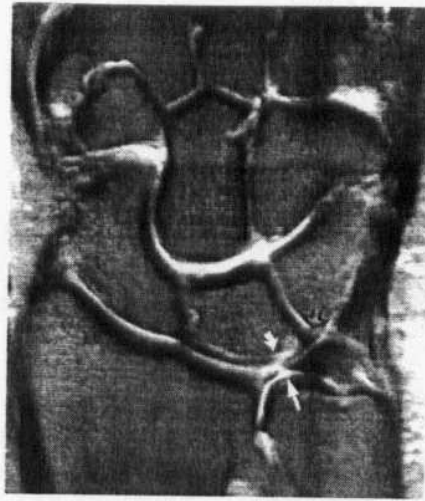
Class IIC lesion with central TFC perforation (straight arrow) and lunate chondromalacia (curved arrow) on a fat-suppressed T2-weighted fast spin-echo coronal image. No intraarticular contrast was required to facilitate the diagnosis. The LT ligament is intact (open arrow). Tapering of the edges of the TFC is seen in degenerative (class II) lesions whereas traumatic (class I) tears tend to have abrupt or straight margins(Quoted from Stoller 1997).
